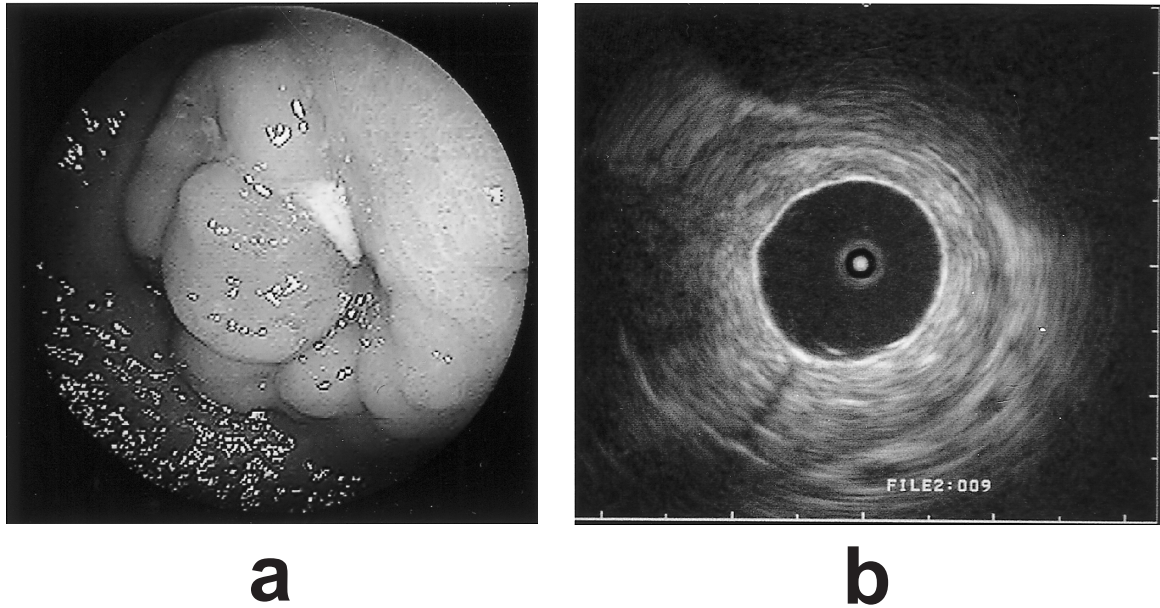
(a) Gastrointestinal endoscopy demonstrated stenosis of the pylorus, which accompanied nodular thickness and ulceration. It was difficult to pass the fiberscope through the ring. (b) Endoscopic ultrasonography using miniature probe with balloon (OLYMPUS: UM-BS20-26R 20MHz) presented circular transmural thickening for all layers of the gastric wall in the proximal side of the stenosis. The length of markers included in the figure was 5 mm for a mark.
